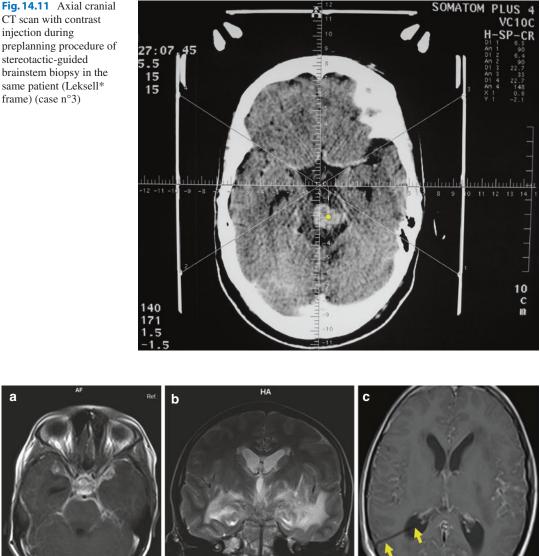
Brain MRI on axial enhanced- T1-weighted image (a) and coronal T2-weighted image (b) of a patient with meningoencephalitis (Note the prominent exudates involving the basal meninges and the extensive brain
